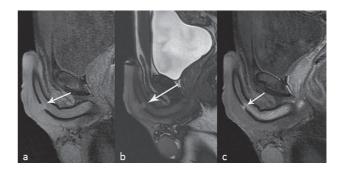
A 30-year-old patient with penile fracture of the right corpus cavernosum. (a) Sagittal T1-weighted image shows a rupture of the tunica albuginea (arrow). (b) The lesion of the tunica albuginea and soft tissue haematoma surrounding the corpus cevarnosum can be detected on T2-weighted images (arrow). (c) Eight weeks later after surgery, the tunica albuginea in healing process showed heterogeneous signal on unenhanced T1-weighted image (arrow).
